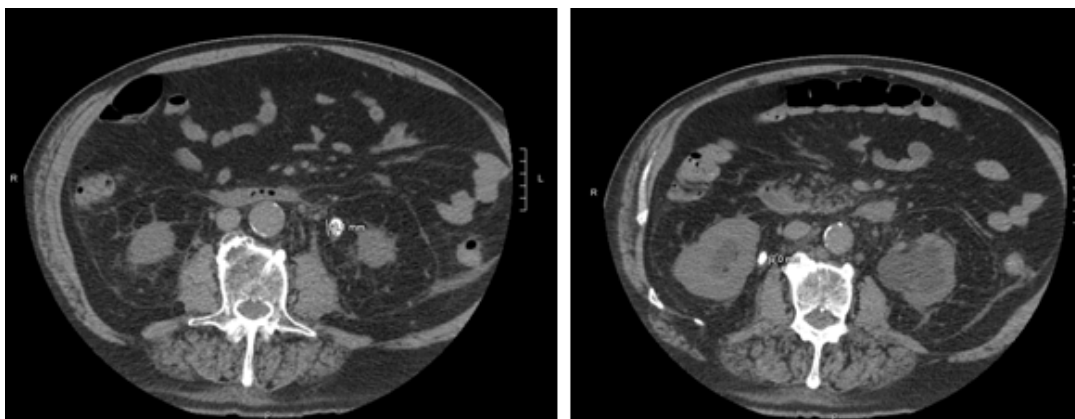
CT scan showing bilateral ureteral stones
